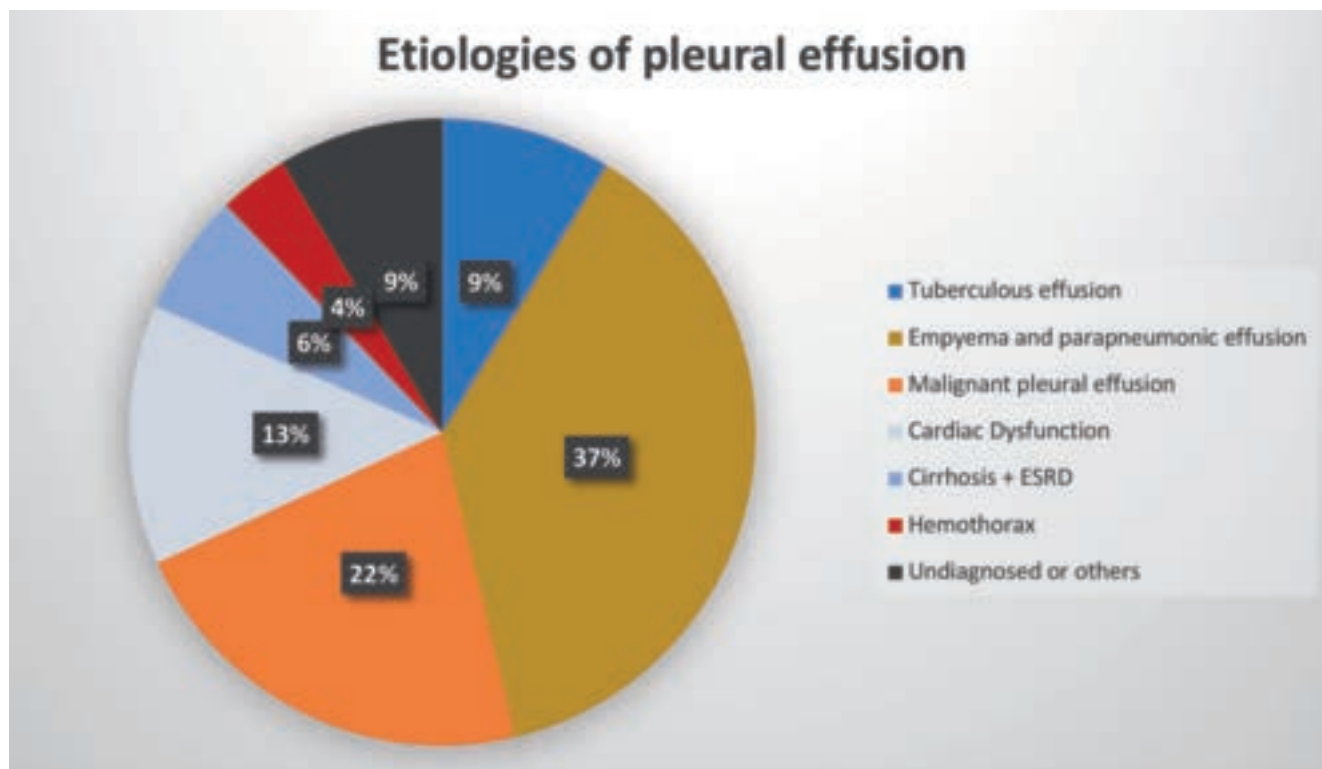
A pie chart depicting different etiologies of pleural effusions that were drained under handheld ultrasound guidance. Of the 72 malignant pleural effusions, 12 were due to hematological malignancies and 60 were due to solid organ malignancies. There were 12 tube thoracostomies done for hemothoraces, 5 were hemothoraces due to trauma, and 7 were spontaneous hemothoraces due to malignancy and/or anticoagulation. All patients with end-stage renal disease were on hemodialysis. ESRD, end-stage renal disease.
